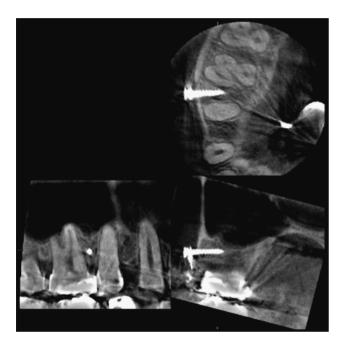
Post-surgical follow-up computed tomographic image of a 33-year-old female patient. The screw was separated from the root.
